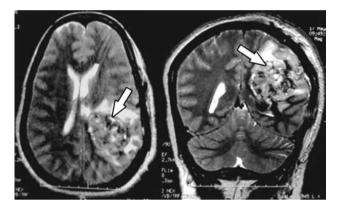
Patient MRI showing a) T2 weighted axial, and b) coronal images after the first surgery showing a left parietal round-shape mixed intensity image surrounded by a hypointense rim.
